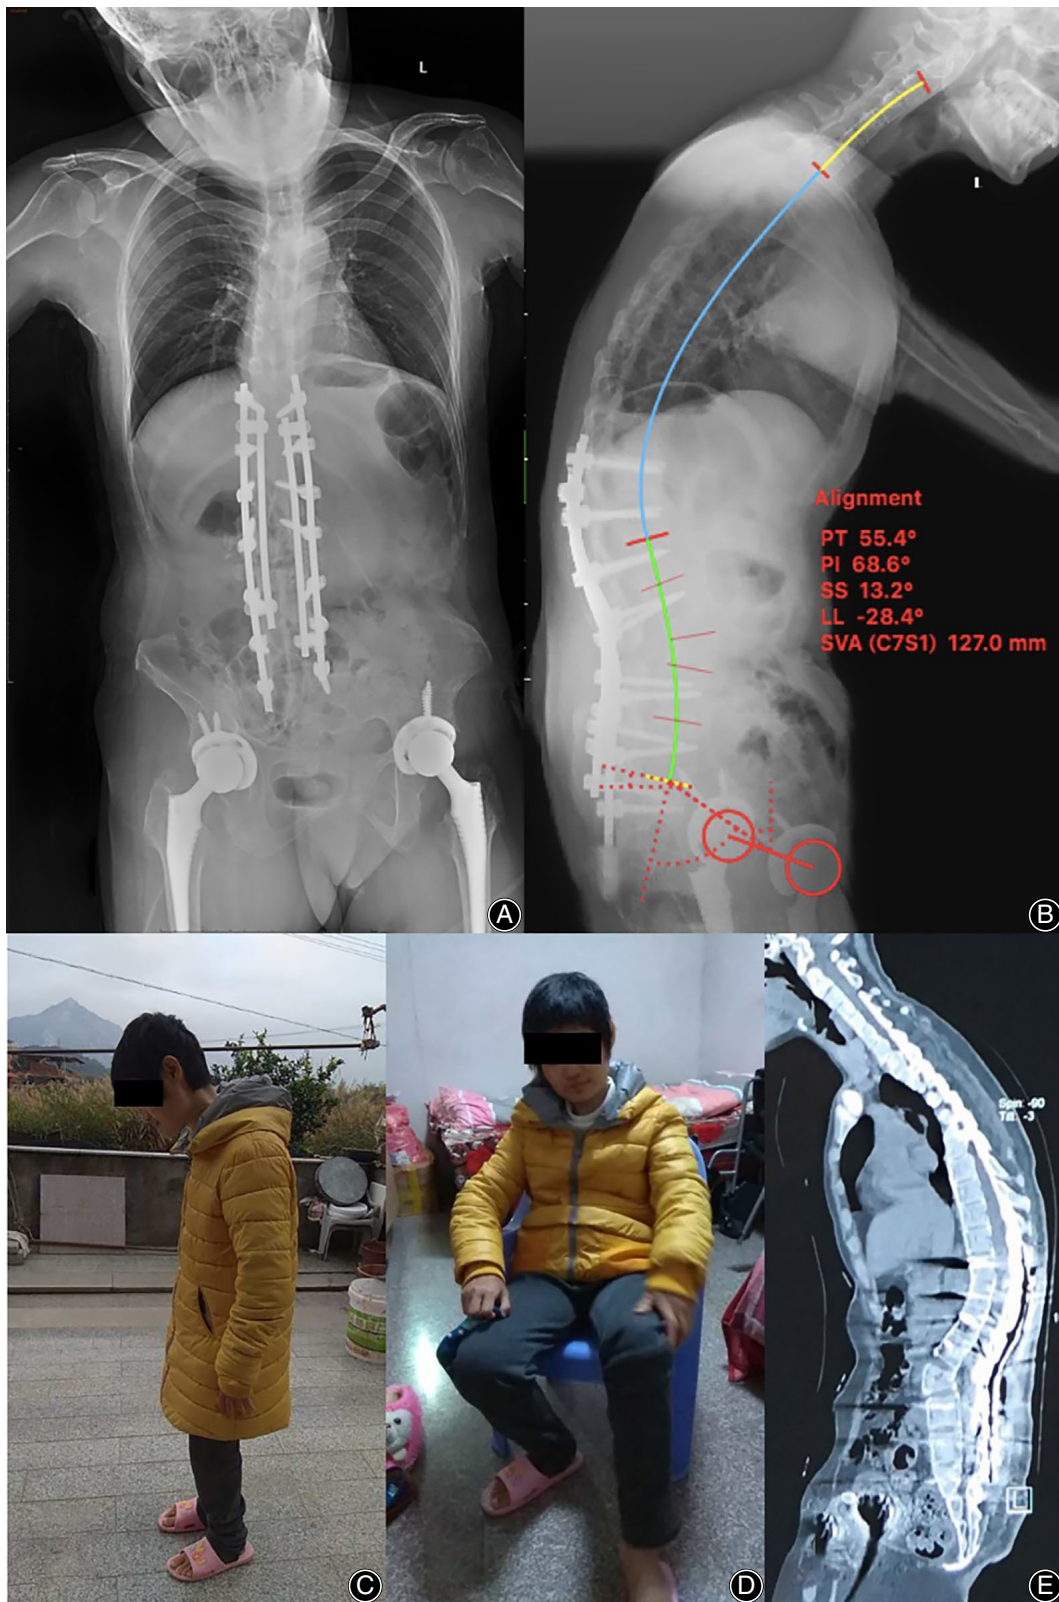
(A, B) Anteroposterior and lateral standing X-ray of patient 1 after PSO at L₃. LL, PT and SVA were -28.4° , 55.4° and 127 mm respectively. (C, D) Six months after PSO, the photographs showed good posture for standing and sitting in patient 1. (E) The CT scan of the spine revealed bone fusion of the osteotomy site at six months follow-up.
